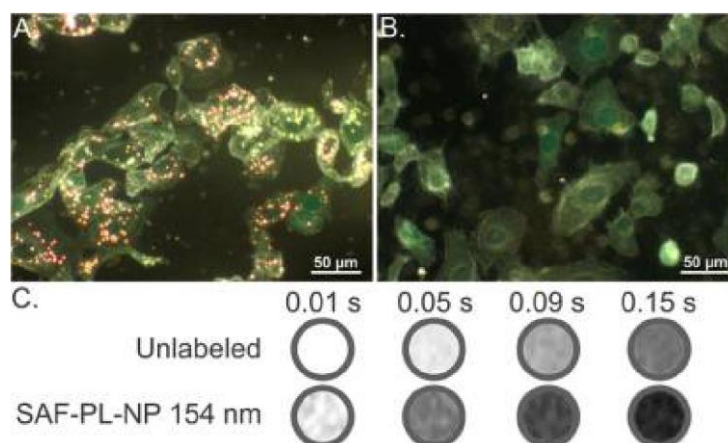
(a) Dark-field image of SKOV3 cells after overnight incubation with 154 nm phospholipid-coated SAF NPs (SAF-PL-NPs); (b) darkfield image of unlabelled SKOV3 cells; (c) MR images of labelled and unlabelled SKOV3 cells at various echo times. Adapted with permission from [428]. Copyright 2014 American Chemical Society.
